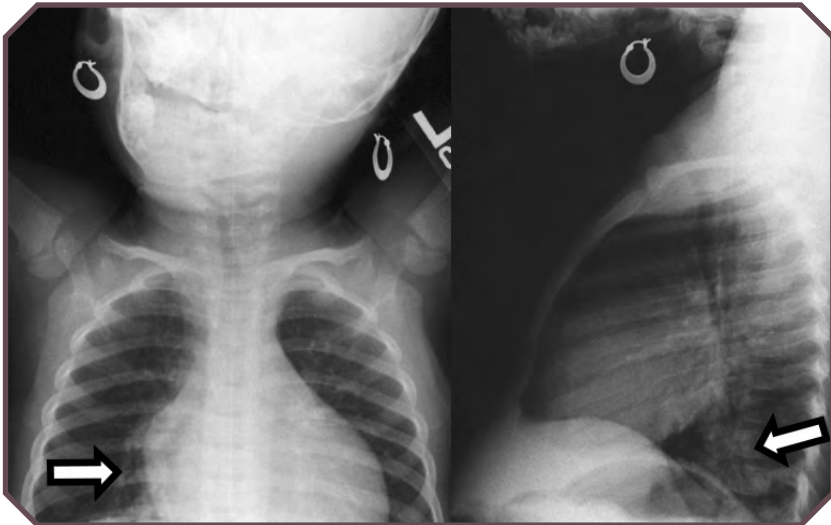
Plain frontal (left) and lateral (right) radiographs obtained in a 2-year-old girl with profound hypoxemia and suspected pulmonary arteriovenous malformation. Note the focal consolidation in the right lung base (arrows) and poor visualization of the right hemidiaphragm on the lateral projection.
